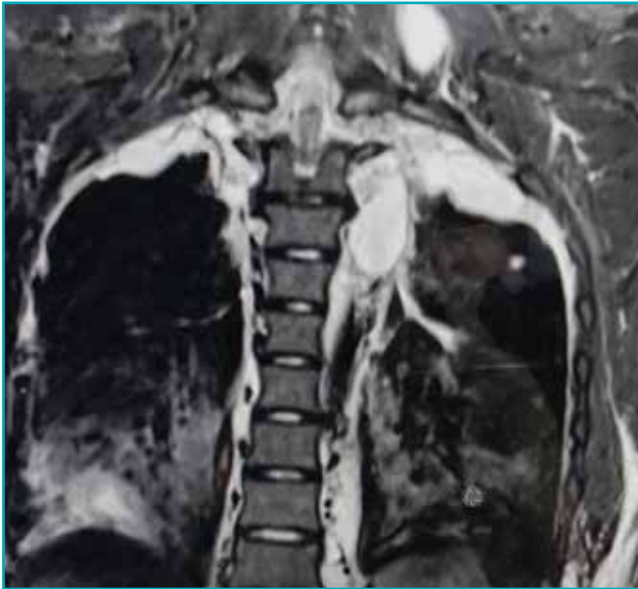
T2-weighted magnetic resonance imaging (MRI) coronal images showing multiloculated enhancing abscesses along the intermuscular and intramuscular planes, along the mediastinal and pleural surfaces.
